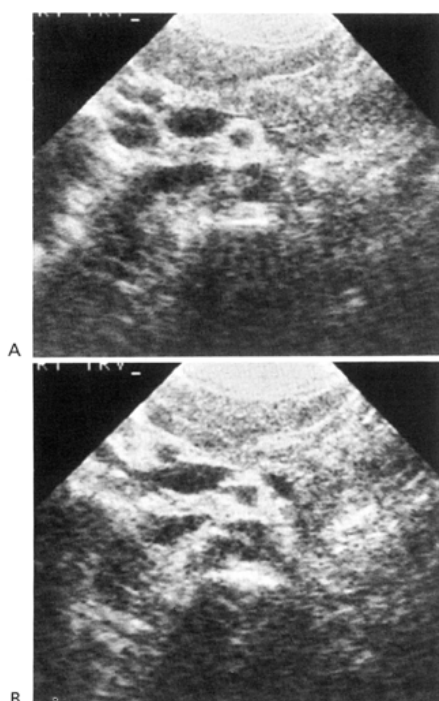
A-B: Acquired cystic kidney disease in a 52-year-old woman on chronic dialysis. Renal ultrasonography reveals small kidneys with increased cortical echoes as found in chronic renal disease. Multiple cysts are present and are of varying sizes.
